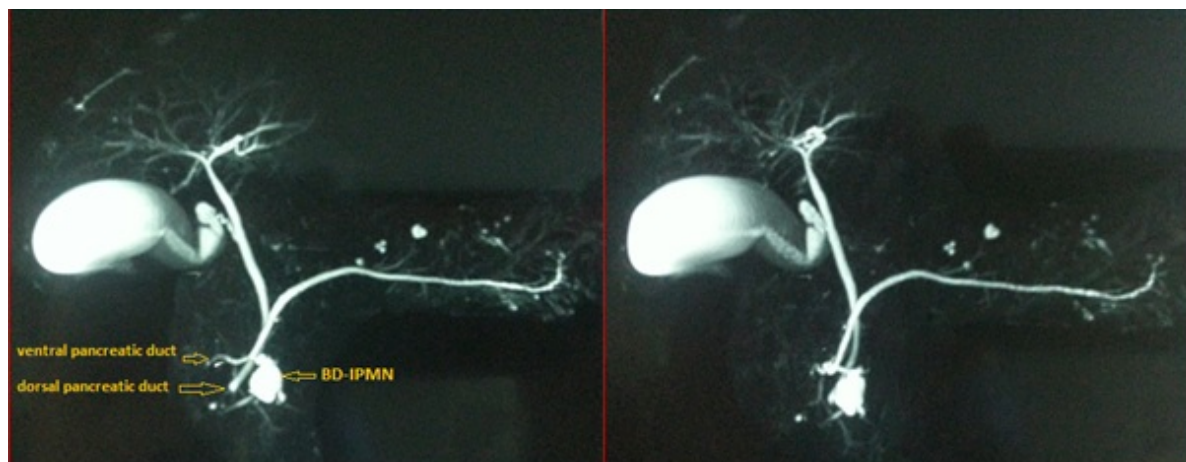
A pancreatico-MRI showing a Warshaw type I pancreas divisum aspect associated with a 2.5 cm cystic lesion developed at the ventral pancreas.
